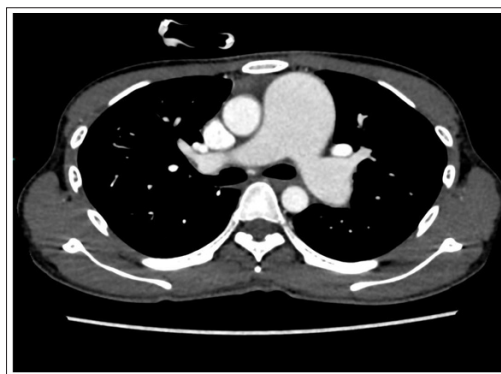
CT Pulmonary Angiogram Image Showing a Very Dilated Pulmonary Artery Trunk. Aortopulmonary Ratio >1:1
